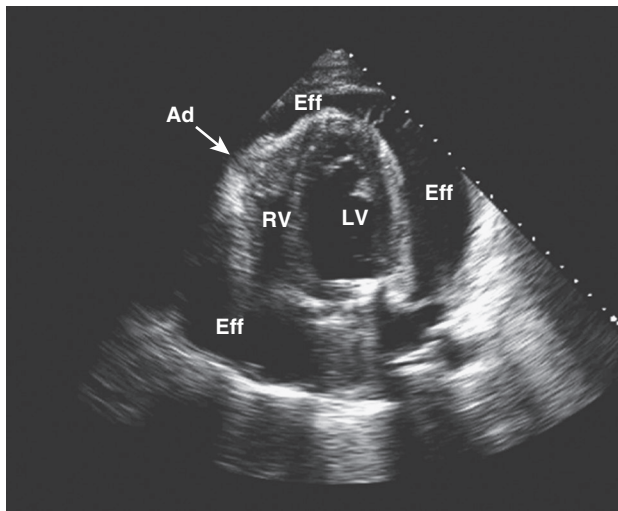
Echocardiogram showing pericardial tamponade with right-sided collapse, adhesion of the right ventricle to the pericardium (arrow), and fibrous strands of early adhesions seen at the 1 o'clock position near the apex of the left ventricle. Even if the effusion accumulates further, electrical alternans would be less likely because of lack of mobility of the heart. Ad, adhesion; Eff, effusion; LV, left ventricle; RV, right ventricle.
